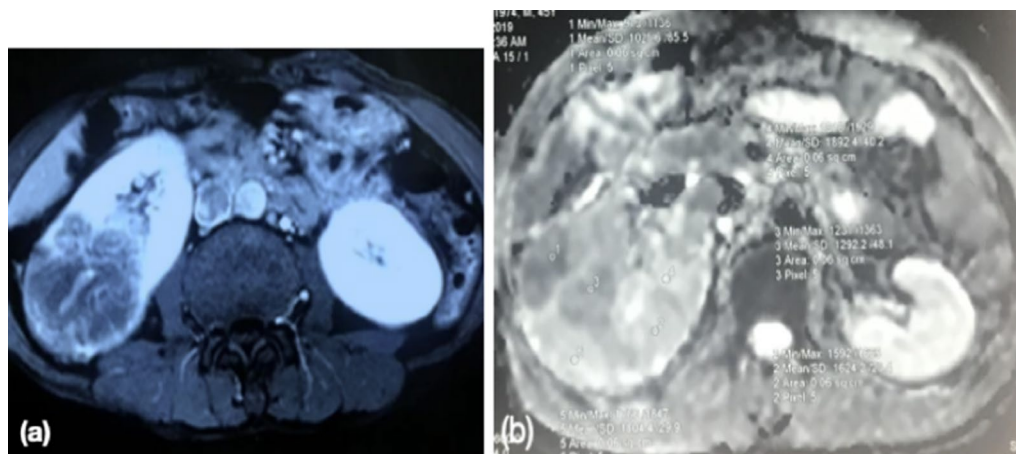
a Transverse section of T2 weighted MRI depicts lower and mid polar right renal mass (T2bN1M0) and b transverse section of DW MRI (ADC map) of right renal mass (lymph node ADC value $1.04 \times 10^{-3} \text{ mm}^2/\text{s}$)
